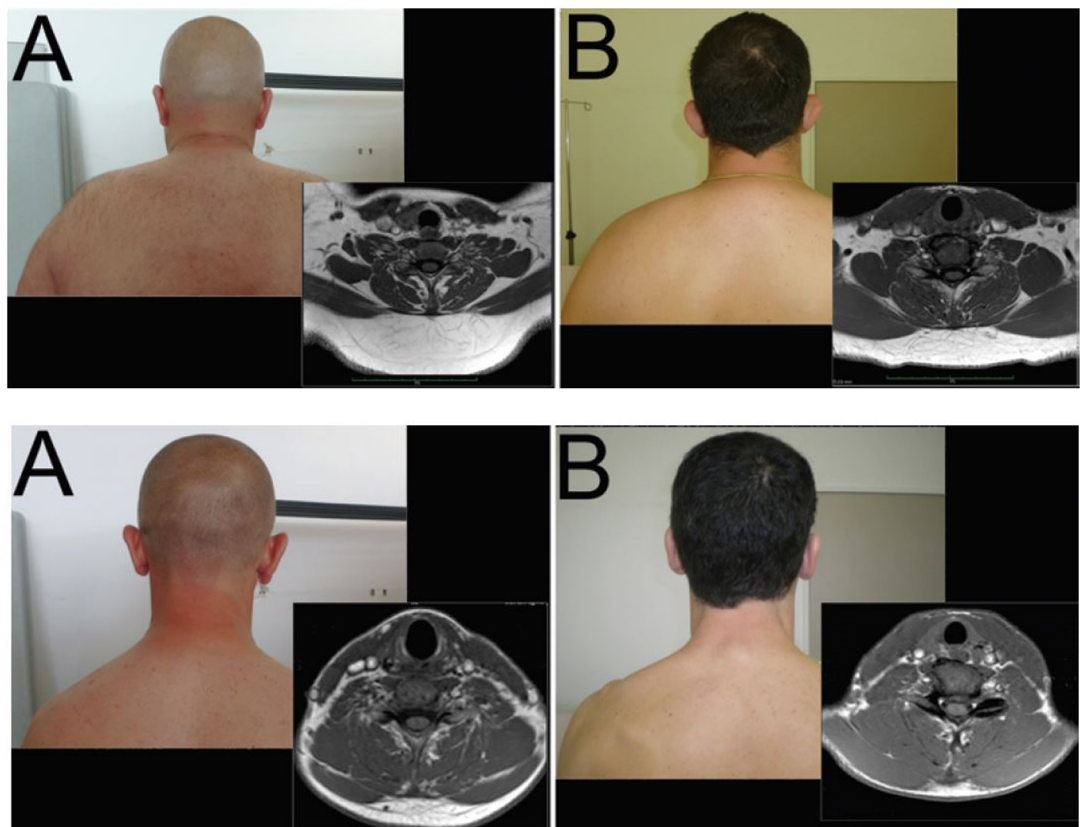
Axial MRI images and photographs showing differences in neck muscle volume and fat deposits (C6-C7 level) between matched controls (A) and former international forward (above) and back (below) rugby player. Adapted from *Brauge et al. (2015) [16]*.
